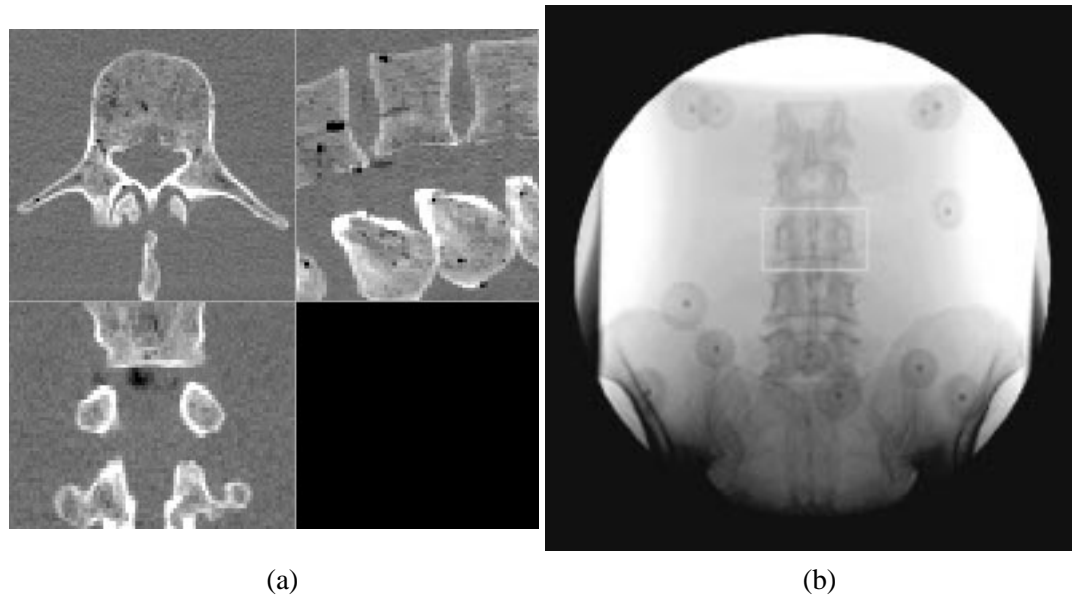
Reformatted axial, sagittal and coronal slices through the reduced CT volume surrounding the L3 vertebra (a). Fluoroscopy image showing region of interest (white rectangle) used for registrations to the L3 vertebra (b).
